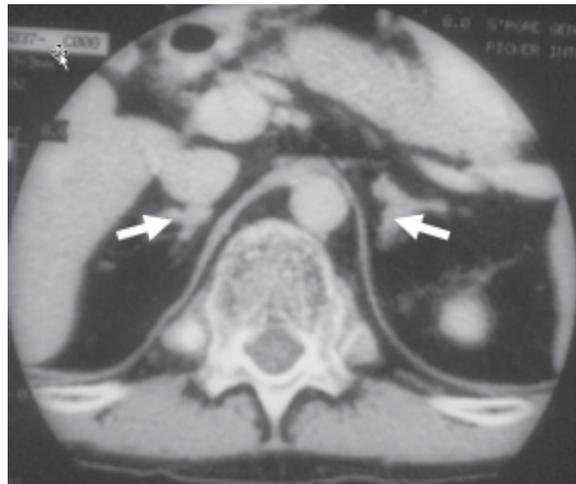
CT scans of the adrenals showing the adrenal nodularity (arrow).
